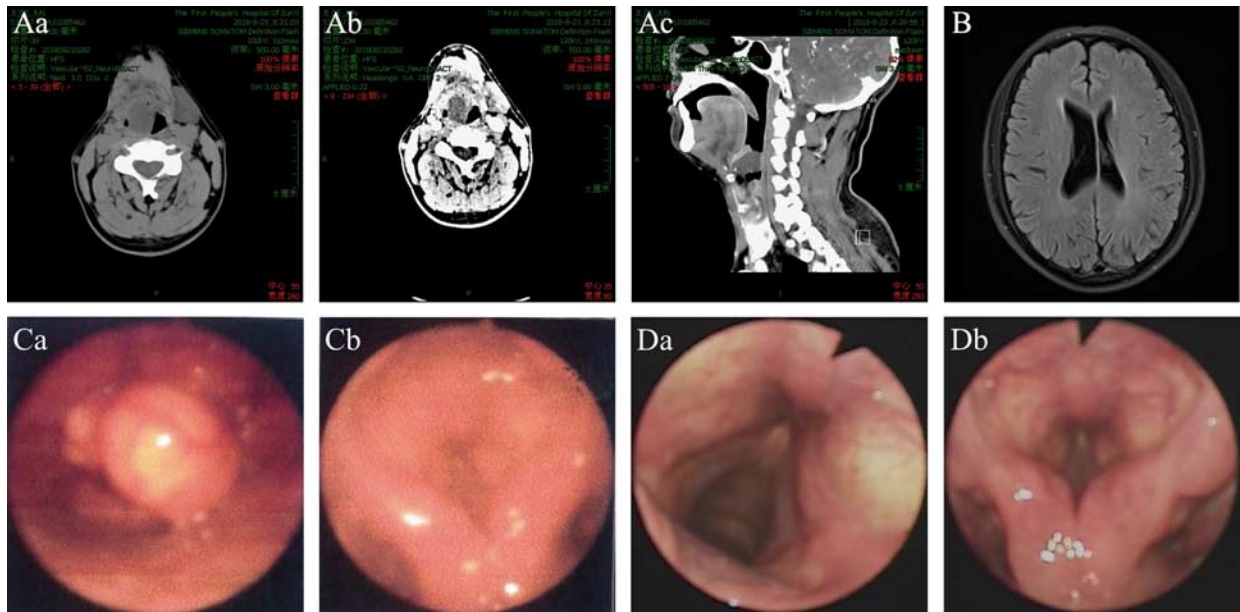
(A) Computed tomography results of the neck: a, plain scan cross-section; b, enhanced cross-section; c, sagittal plane. (B) Magnetic resonance imaging results of the brain. (Ca and Cb) Preoperative laryngoscopy. (Da and Db) Laryngoscopy 2 months after surgery.
